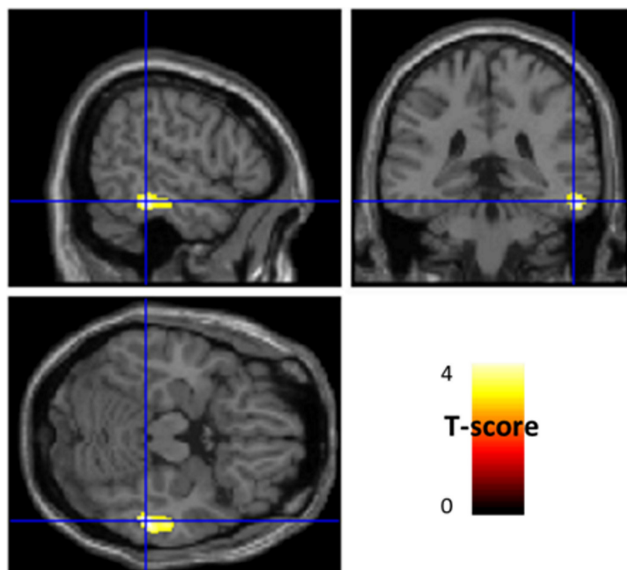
Anatomical localization of areas of increased metabolism in ICD patients in comparison to without ICDs ($p < .005$, uncorrected, $k > 130$) projected onto sections of a normal MRI set spatially normalized and smoothed into the standard SPM8 template. In comparison to patients without ICDs, those with ICDs showed a relative increased metabolism in right middle and inferior temporal gyri (BA20–21). ICD: impulse control disorders; MRI: magnetic resonance imaging; BA: Brodmann area [Color figure can be viewed at wileyonlinelibrary.com]
